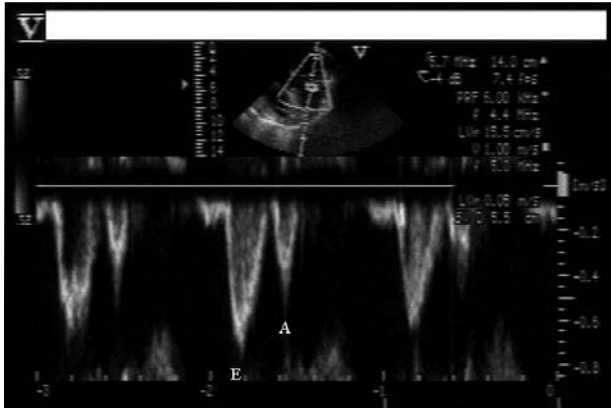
Normal mitral inflow pulsed wave Doppler (E: A ratio > 1) before aortic cross clamping.
